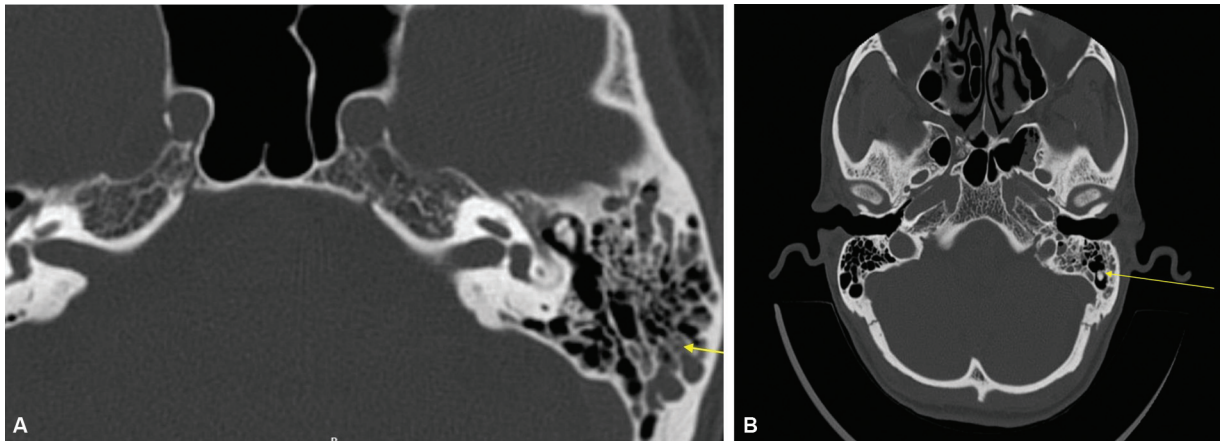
Computed tomographic (CT) scan images of the temporal bone: (A) CT image with arrow pointing to soft tissue density with air-fluid levels in the mastoid air cells. (B) CT image with arrow pointing to osteoma within mastoid air cells.
